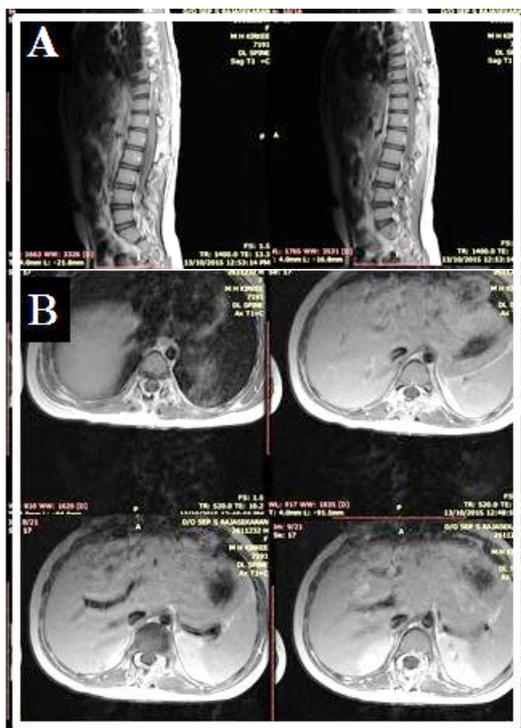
Post Op contrast MRI showing no residual lesion (A- Sagittal, B - Axial)
